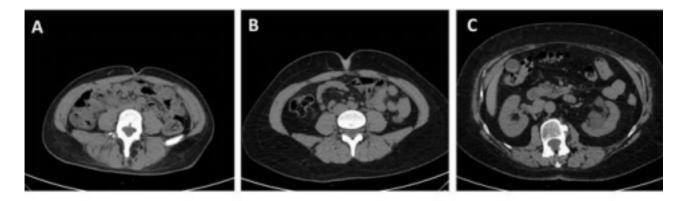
CT axial images acquired at emergency department in basal condition in patient at age 28yrs (A) 46yrs (B) 71yrs (C) showing an increas of total adipose tissue (TAAT) in particular visceral adipose tissue (VAT) rises among older individuals.
